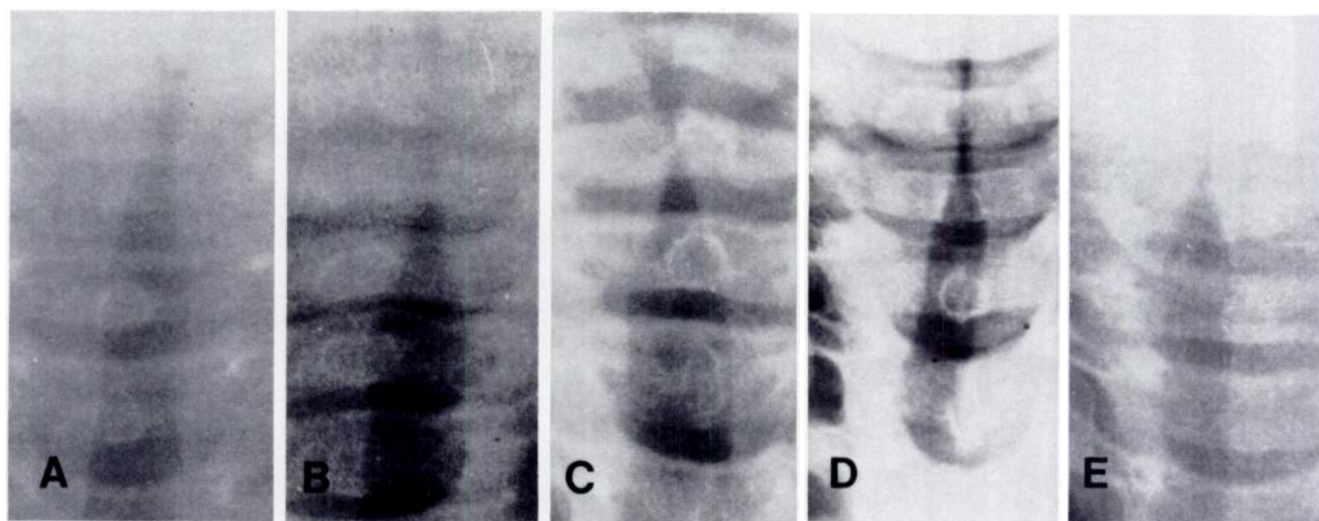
Anteroposterior airway radiographs of five patients who exhibited subglottic edema showing in all cases, fusiform narrowing localized to immediate subglottic region, indistinguishable from croup. A, Case 1. B, Case 2. C, Case 3. D, Case 4. E, Case 5.
